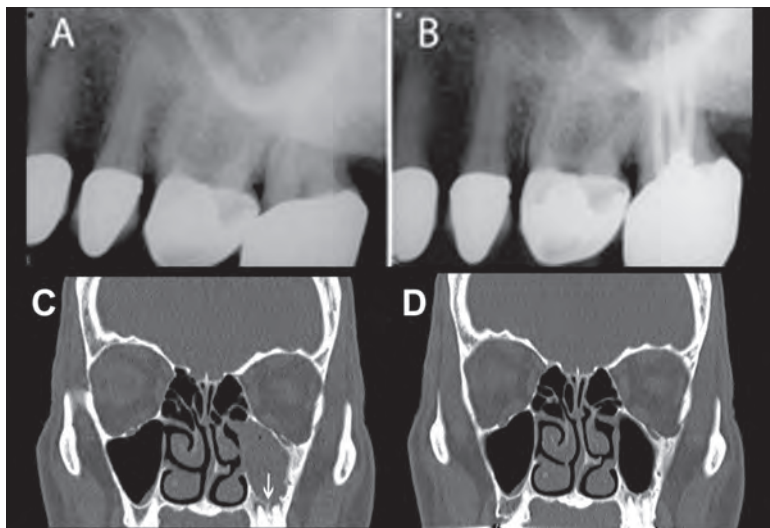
Maxillary sinusitis of dental origin. A, Preoperative periapical radiograph. Note the limited diagnostic value due to zygomatic and palatine processes obscuring the molar root apices. Periapical infection is not evident. B, Endodontic treatment completed on tooth #15. C, Coronal CT scan reveals periapical abscesses on both the buccal and palatal roots of tooth #15, and the extension of the dental infection into the floor of the left maxillary sinus via the broken cortical bone (*arrow*). Note the fully obstructed left maxillary sinus indicating an advanced sinus infection. D, Ten-week follow-up after RCT. CT scan showing full resolution of the sinus disease. All sinus symptoms have resolved, and the patient is free of antibiotics and adjunctive sinus regimens for the first time in 2 years.
